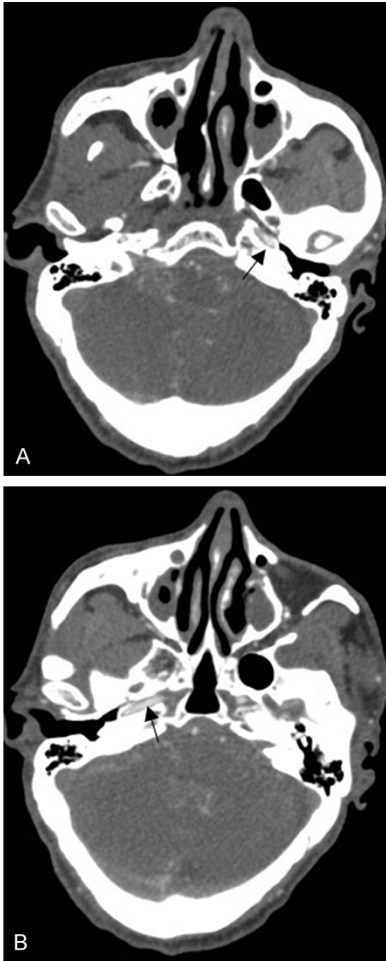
Enhanced thin-layer CT images of the head. (A, B) A thin-layer enhanced CT scan of the skull base shows the carotid artery canal, inside of which the artery develops well. (A) shows the left side, and (B) shows the right side (black arrow). (C) The vertebral artery traveling through the transverse foramen, indicated by a black arrow.
